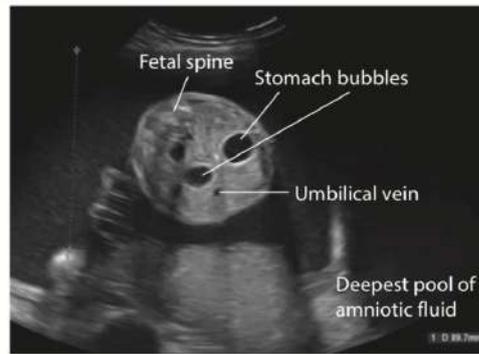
Ultrasound image showing the 'double bubble' appearance and polyhydramnios associated with duodenal atresia.
